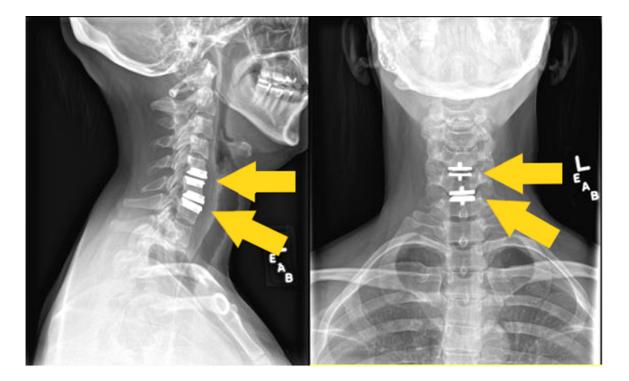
Radiograph of C6-7 after cervical total disk replacement. The cervical total disk replacements of both the C5-6 and C6-7 disks are visible in these lateral (left) and posteroanterior (right) radiographs.
